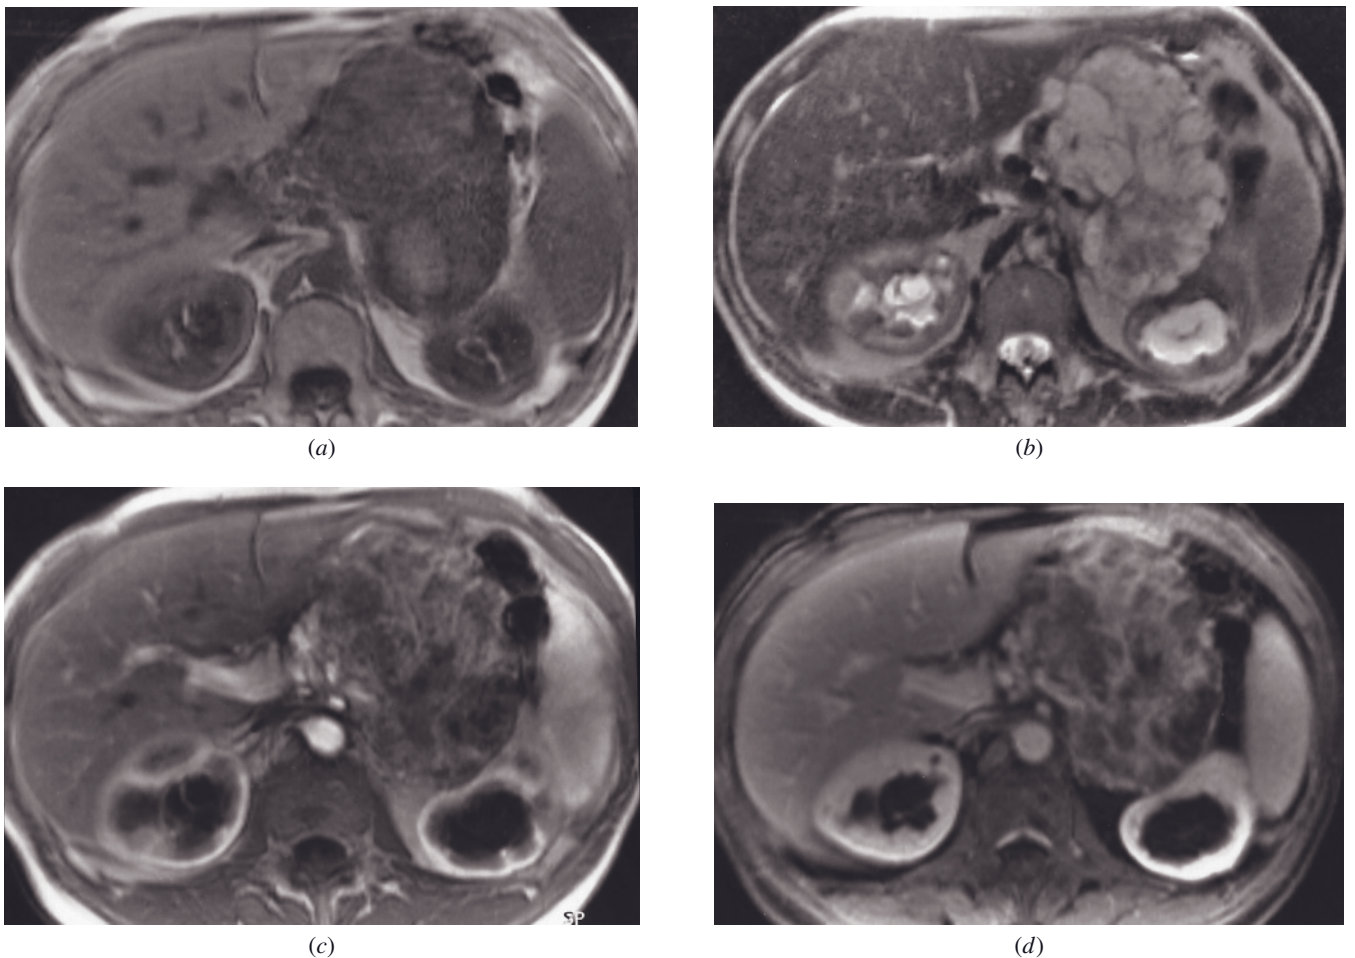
Macrocystic serous cystadenoma. T1-weighted SGE (*a*), T2-weighted SS-ETSE (*b*), immediate postgadolinium T1-weighted SGE (*c*), and 90-s postgadolinium fat-suppressed SGE (*d*) images. A 10-cm mass arises from the tail of the pancreas. The tumor is mildly hypointense with regions of hyperintensity on precontrast T1-weighted images (*a*). Multiple septations are present throughout the mass, well shown on the breathing-independent T2-weighted image (*b*). Some of the cysts measure >2 cm. Moderately intense enhancement of the septations is present on immediate (*c*) and 90-s (*d*) postcontrast images.
